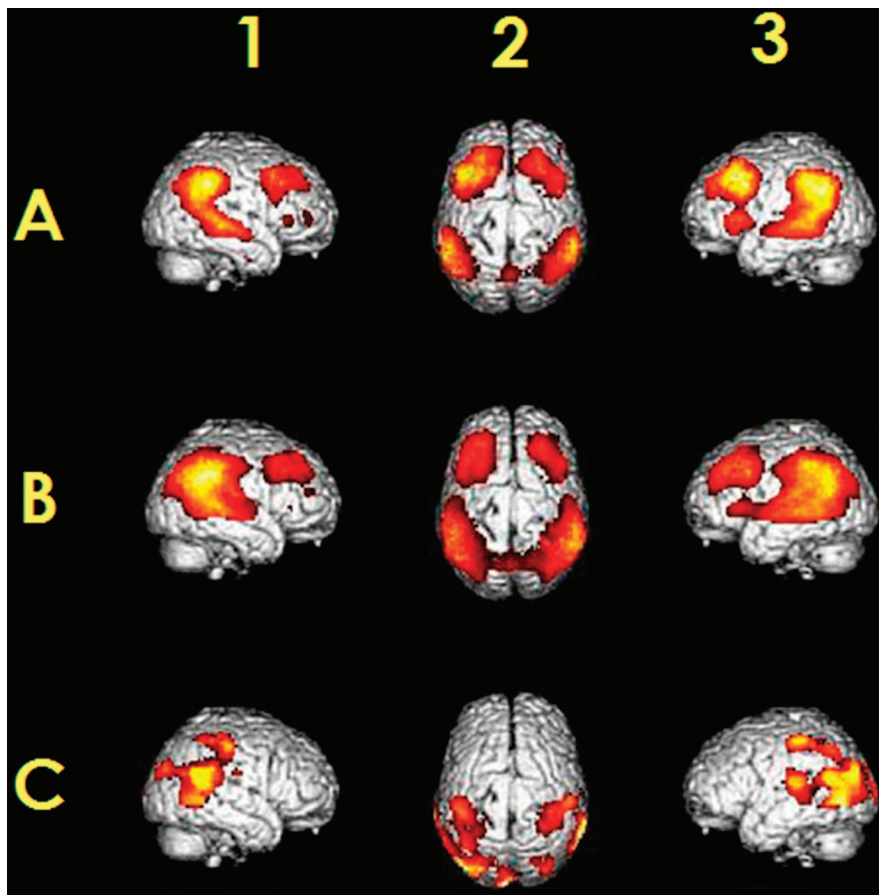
Cerebral metabolic abnormalities in APOE $\epsilon 4$ -positive and -negative patients with Alzheimer disease (AD). Images 1 to 3 show results superimposed on a standard MRI surface: 1 = right lateral aspect; 2 = cranial aspect; 3 = left lateral aspect. (A) Cerebral metabolic deficits in APOE $\epsilon 4$ -negative patients with AD as compared with healthy volunteers. (B) Cerebral metabolic deficits in APOE $\epsilon 4$ -positive patients with AD as compared with healthy volunteers. (C) Stronger cerebral metabolic deficits in APOE $\epsilon 4$ -positive patients as compared with APOE $\epsilon 4$ -negative patients.
